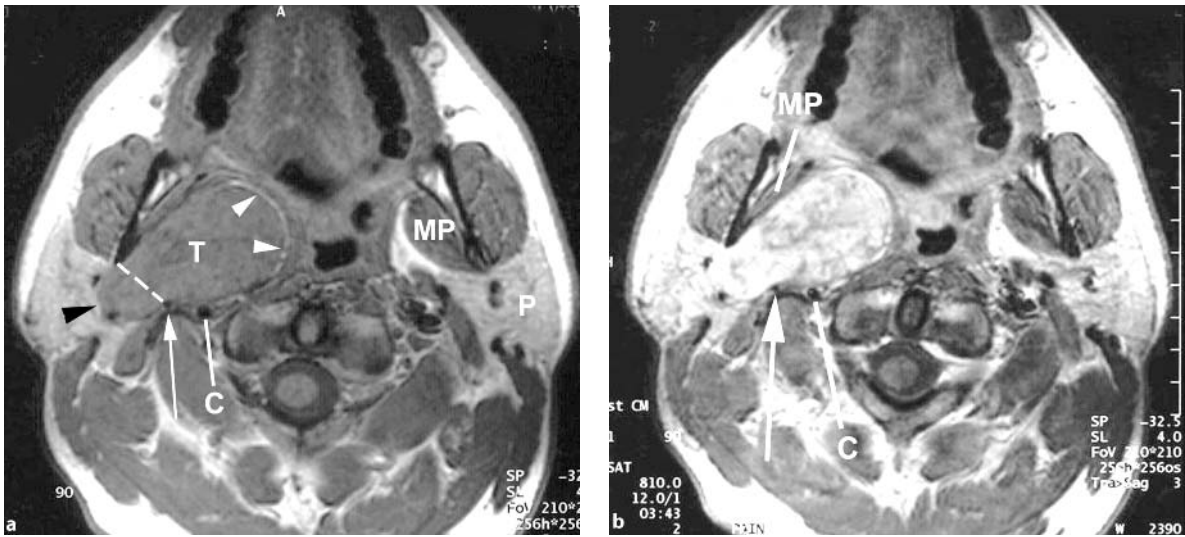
Pleomorphic adenoma arising in the prestyloid parapharyngeal space, MRI. a T1-weighted image without contrast. The tumor (*T*) fills the prestyloid parapharyngeal space. The tumor pushes the parapharyngeal fat anteromedially (*white arrowheads*). Laterally the lesion pushes beyond the plane of the stylomandibular tunnel (*dashed line*). The lateral margin (*black arrowhead*) displaces the retromandibular vein laterally. The key landmarks in identifying a lesion as arising in the prestyloid space are the carotid artery (*C*) the styloid process (*arrow*), the medial pterygoid muscle (*MP*) and the posterior margin of the mandible. Note the normal appearance of the parotid gland (*P*) on the left. b Axial T1-weighted image postcontrast. The lesion shows enhancement typical of pleomorphic adenoma. Carotid (*C*), styloid process (*arrow*), compressed and displaced medial pterygoid muscle (*MP*)
